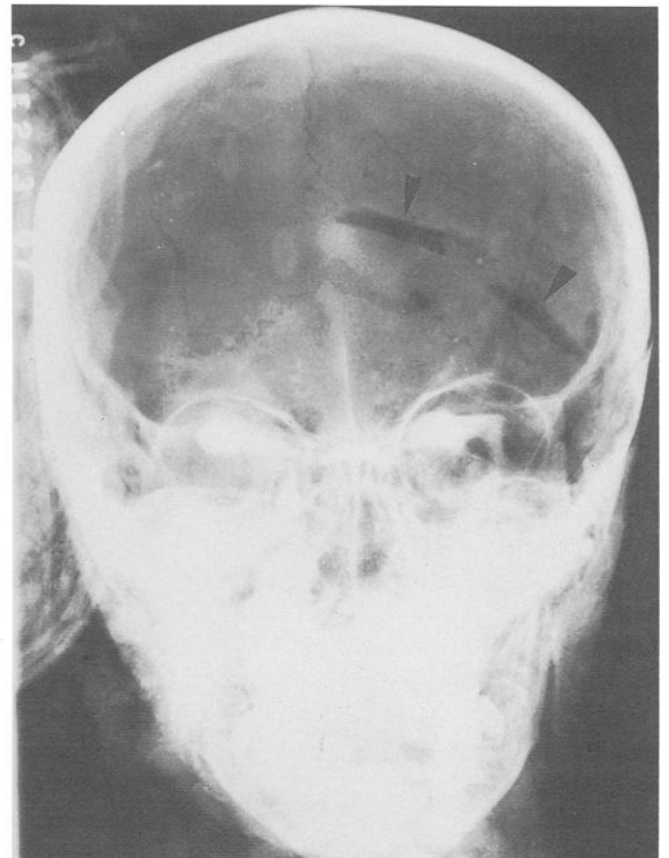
Postmortem frontal radiograph of the skull demonstrates the two surgical defects (arrowheads) superior to the left lambdoid suture.
